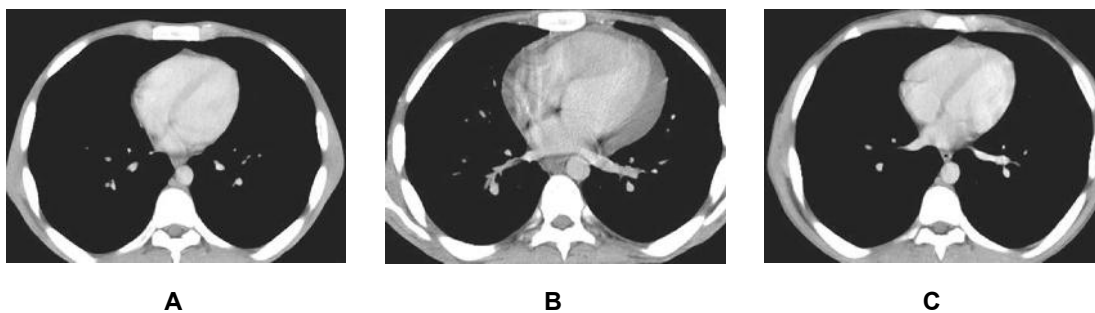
23-year-old male with HD. Patient received 6 cycles of BEA-COPP. Follow up CT chest. A- Before the start of chemotherapy. B (mediastinal window). Mild to moderate pericardial effusion. C- Marked improvement after termination of chemotherapy treatment
